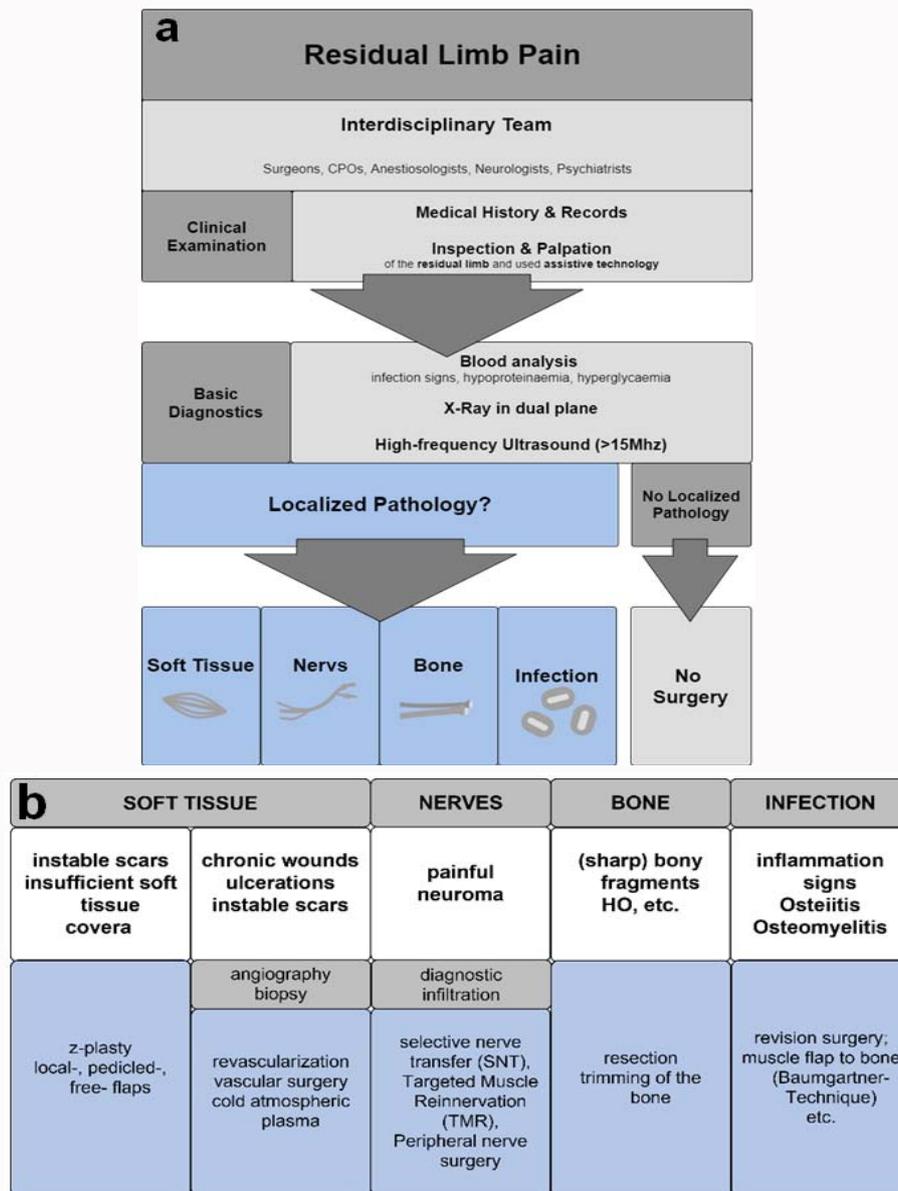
a) Algorithm which serves as worksheet of the interprofessional “Interdisciplinary Amputee Outpatient Clinic”. The evaluation starts with a physical examination by an interprofessional team of an orthopedic surgeon, plastic surgeon, prosthetist and occupational therapist. If needed a neurologist and pain therapist were involved. Recorded were conditions of amputation- past medical history and past treatment followed inspection and palpation of the residual limb for localizing the pain sites and identification of neuromas (Hoffmanns Tinel’s sign) insufficient or excessive soft tissue coverage and painful scars. Prosthetic alignment, socket suspension, pharmaceutical and non-pharmaceutical pain treatment were reevaluated. After physical examination, diagnostic followed: Dual-plane x-ray of the residual limb in dual-plane to localize and identify bony fragments or foreign bodies; high-resolution ultrasound image neuroma if the physical examination confirmed positive Hofmann-Tinel’s sign. In case of positive medical history and clinical signs for infection diagnostics included blood analyze and additional imaging (MRI, CT-Scans). b) If the algorithm reveals a or a combination of localized pathology as soft tissue complications, nerves, bones or an infection- (surgical) interventions including revision surgery following surgical principles and the reconstructive ladder (highlighted in light blue) should address the target to relieve pain (Ernst et al., 2017).
